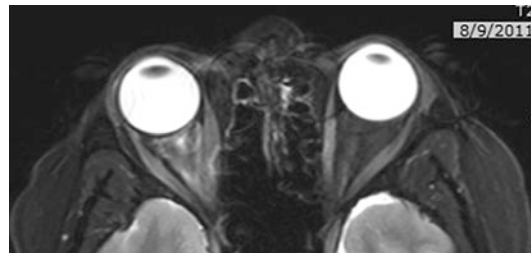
A 47-year-old female with a prior history of treated nonmetastatic breast cancer presented with amaurosis; clinical examination was notable for right-sided enophthalmos, and T2-weighted axial MRI showed an extensive right-sided intraconal mass. Orbital biopsy confirmed metastatic breast cancer
